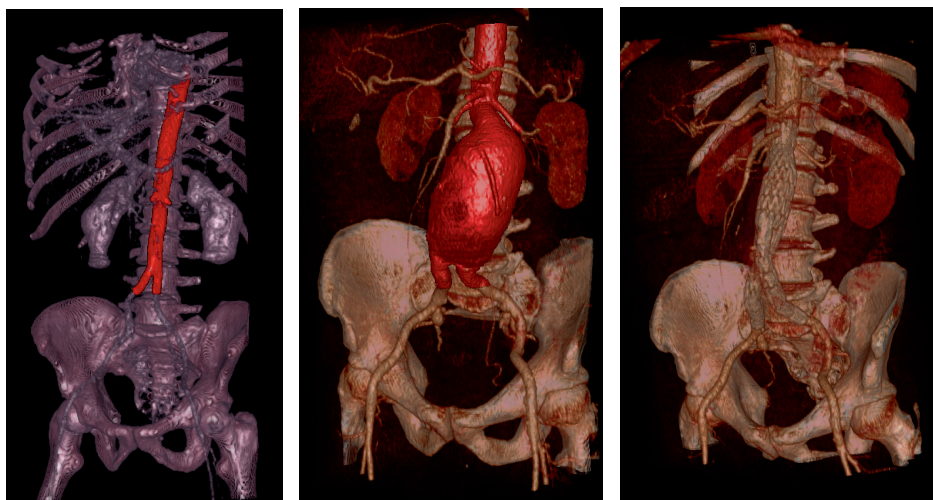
Left: Normal abdominal aorta, mid: AAA and right: w/stentgraft. The aortic wall is segmented from CT using the open-source software ITK snap (www.itksnap.org), and visualized using CustusX (SINTEF, Trondheim, Norway).
